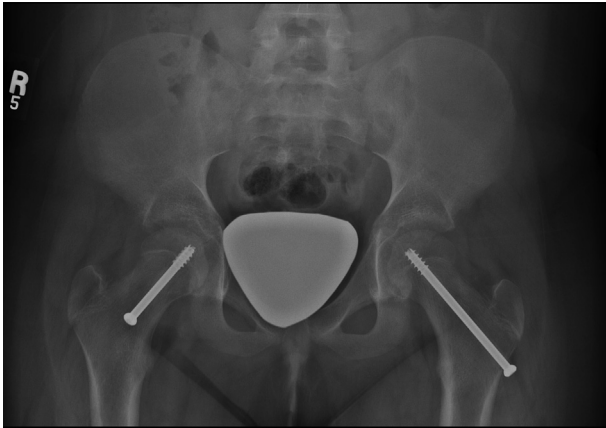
Anteroposterior (AP) pelvis radiograph showing bilateral percutaneous screw fixation for slipped capital femoral epiphysis (SCFE).
